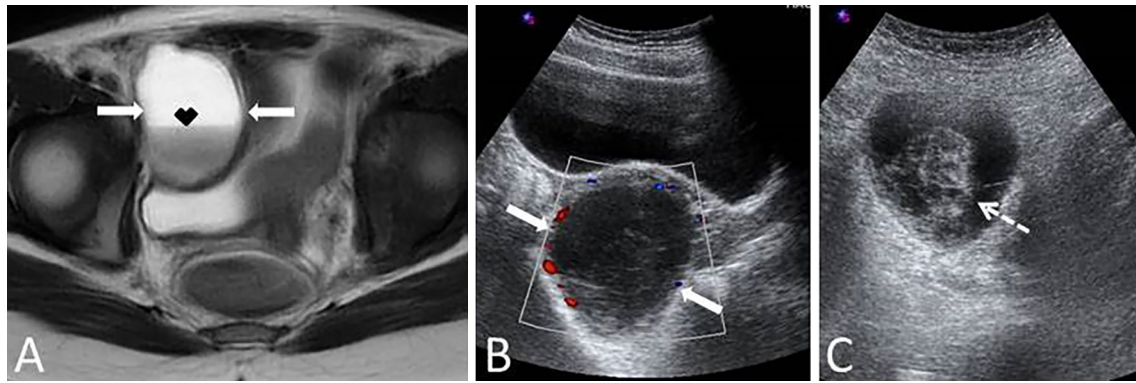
Hemorrhagic ovarian cysts in two different patients. A 20-year-old female patient presenting with pelvic pain. Axial T2W MR image shows a cystic lesion (arrows) with fluid–fluid level (arrowhead) in the right ovary. B and C 32-year-old female patient presenting with acute onset pelvic pain. On US, a cystic lesion
